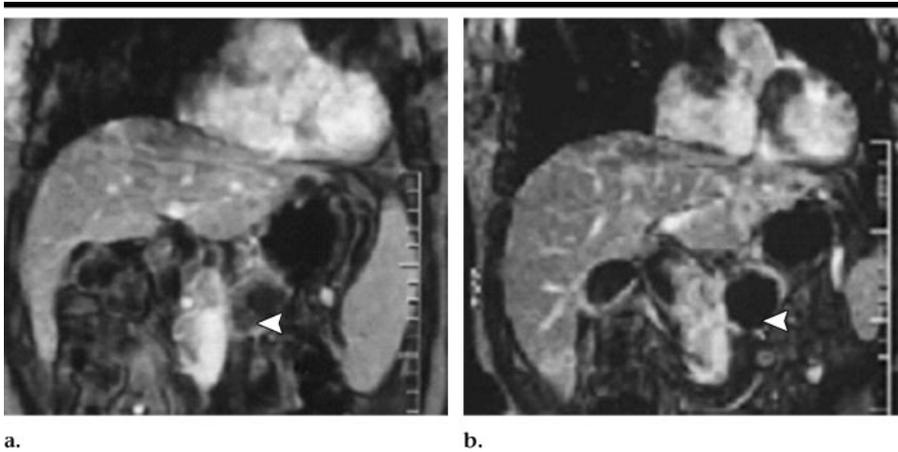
Dynamic contrast-enhanced gradient-echo T1-weighted MR images (180/6.0, 90° flip angle, 128 × 256 matrix, 10-mm-thick sections, 2-mm intersection gap, one signal acquired, and 18-second acquisition time) obtained with breath holding in 48-year-old man who underwent high-intensity focused ultrasound ablation for advanced pancreatic cancer. The tumor was 4.5 × 4.5 cm in diameter and located in the body of the pancreas. (a) Image obtained before high-intensity focused ultrasound shows the blood supply in the pancreatic lesion (arrowhead). (b) Image obtained 2 weeks after high-intensity focused ultrasound shows no evidence of contrast enhancement in the treated lesion (arrowhead), which is indicative of complete coagulation necrosis in the pancreatic cancer.
